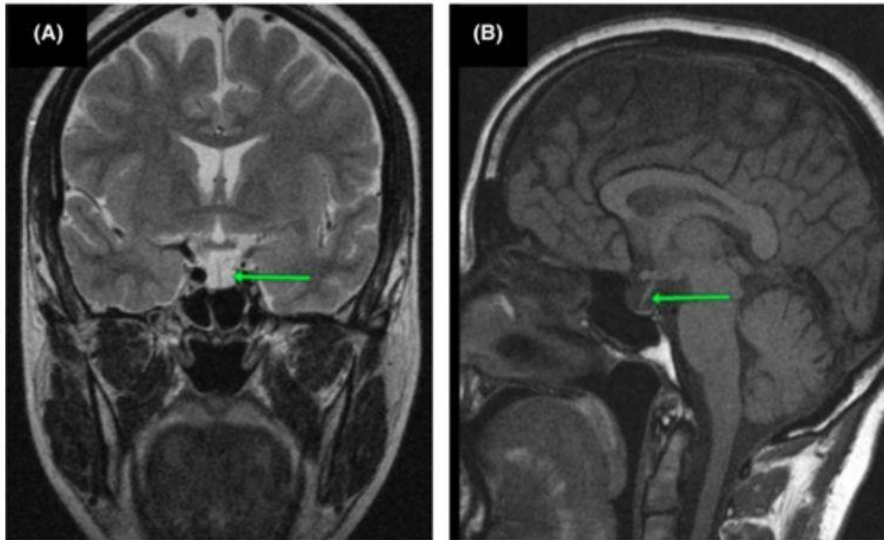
Magnetic resonance imaging of sella. The arrow shows a CSF-filled sella with a thin rim of pituitary tissue and pituitary stalk, indicating an empty sella. (A) T2 coronal section, (B) T1 sagittal section. CSF, cerebrospinal fluid.
